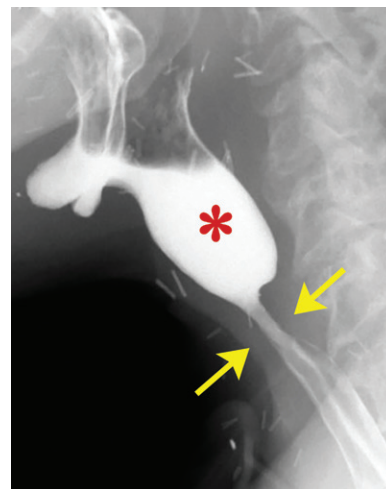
Postradiation stricture in a 75-year-old man. Lateral radiograph of swallowing after total laryngectomy shows a stricture in the neopharynx (arrows), with proximal pharyngeal dilatation (*).
